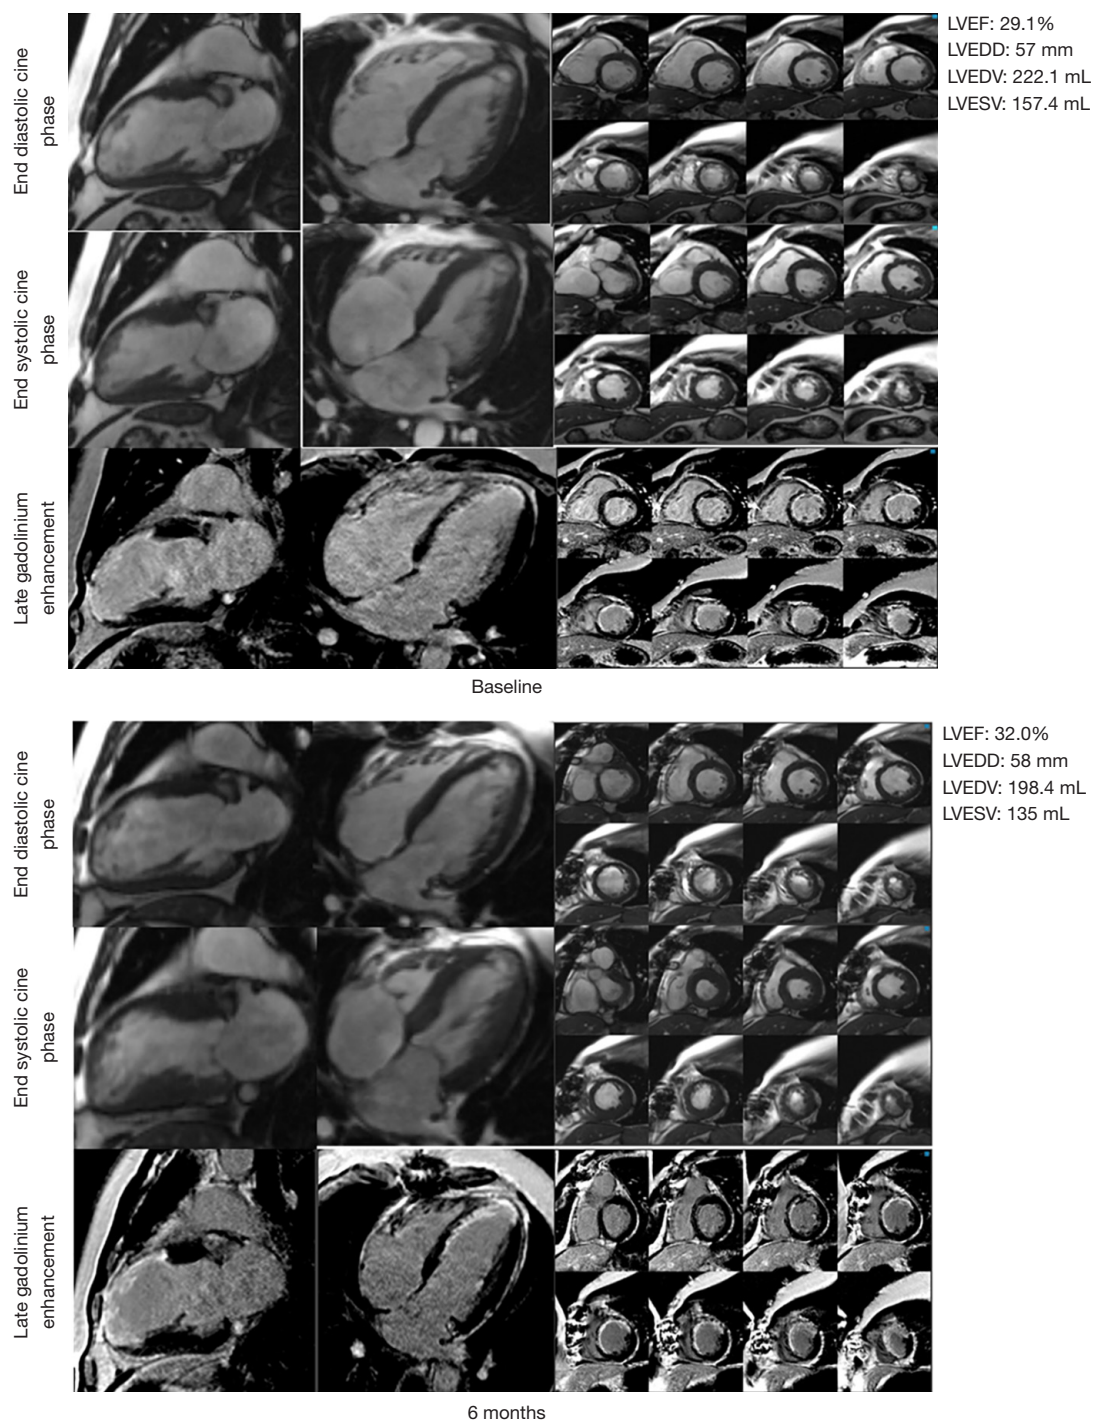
Case 1. The CE-CMR of a patient at baseline and 6 months after I-CABG. Example of CE-CMR images before and 6 months after I-CABG of a 56-year-old man with a 6-scar segment who suffered from congestive heart failure 9 months after surgery. CE-CMR, contrast-enhanced cardiovascular magnetic resonance imaging; I-CABG, isolated coronary artery bypass graft; LVEDD, left ventricular end-diastolic diameter; LVEDV, left ventricular end-diastolic volume index; LVEF, left ventricular ejection fraction; LVESV, left ventricular end-systolic volume.
